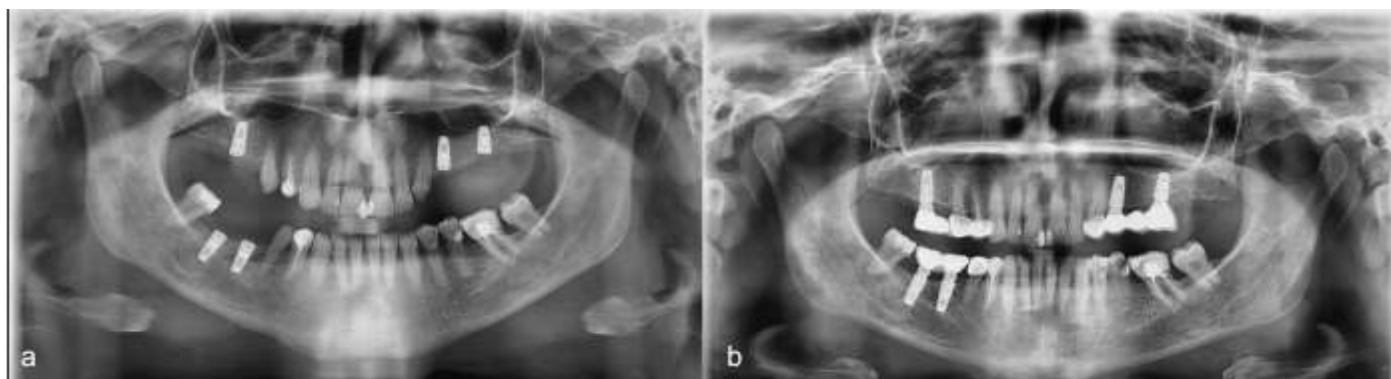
The radiographic visualization of the rehabilitation of a patient. Immediately after implant insertion (left), one year after prosthetic rehabilitation (right). Please note the crestal bone stability.
